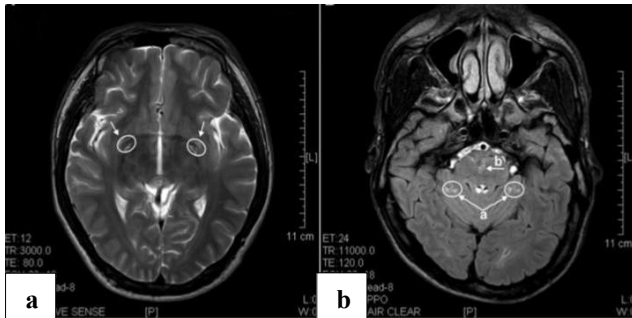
MRI images of the brains of a 4-year-old ketamine addict, (a) T2 image of a horizontal brain section showing degenerative hyperintense spots in basal forebrain (arrow), and (b) T2 image of a horizontal section showing hyperintense degeneration in cerebellum and in pons.⁹
